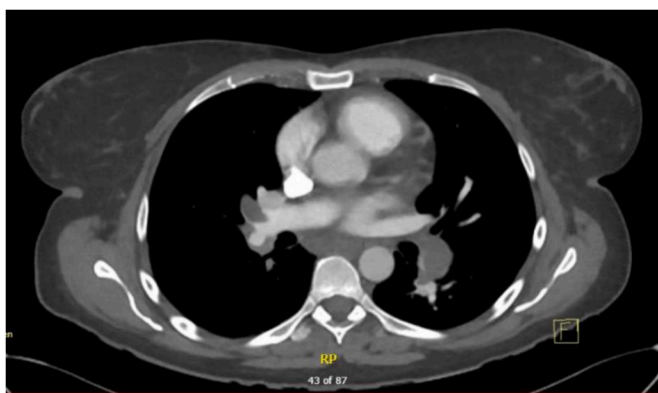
CT pulmonary angiogram demonstrating bilateral sub-massive pulmonary emboli.
